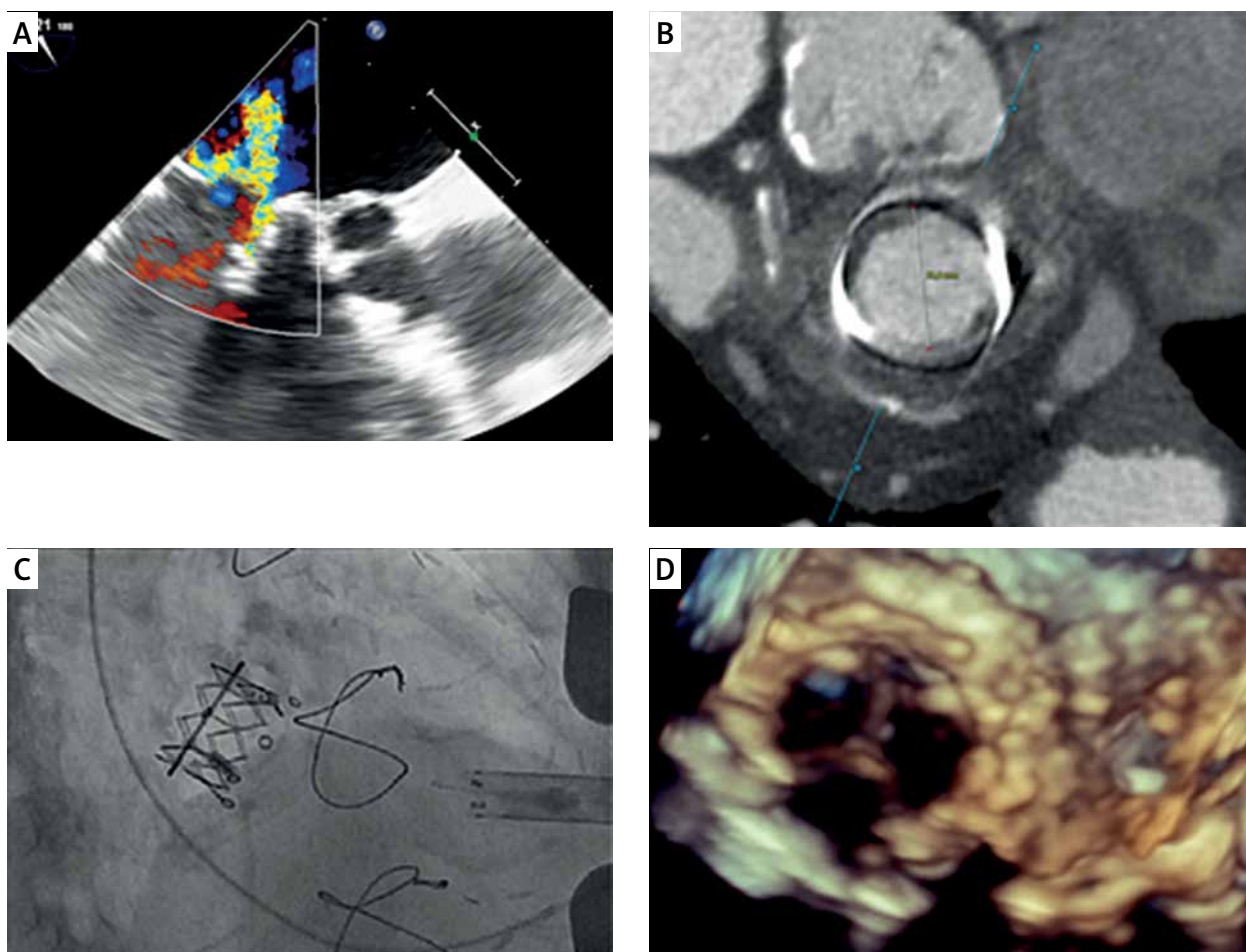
A – Transesophageal echocardiography – severe mitral bioprosthesis regurgitation, B – computed tomography – inner diameter of Hancock II bioprosthesis, C – optimal position of implanted Sapien XT prosthesis, D – three dimensional transesophageal echocardiography – visible good leaflet coaptation of Sapien XT prosthesis
